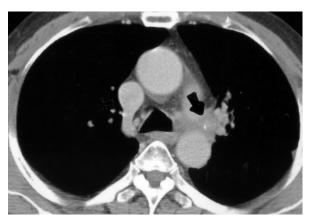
Chest computed tomography imaging showing small cell lung cancer with partial response after concurrent chemoradiotherapy (arrow).
